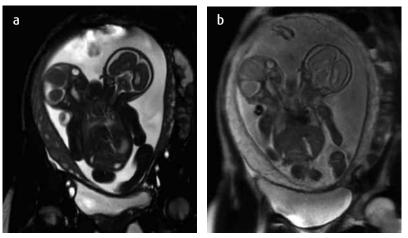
MRI a) Coronal STIR; b) with coronal T2 information. Patient 28.4 weeks gestation. A medial thoracoabdominal junction is seen, with both heads and separate hearts being visualized. Defined medial and medial lateral superior extremities, two lower extremities and a single cord.
